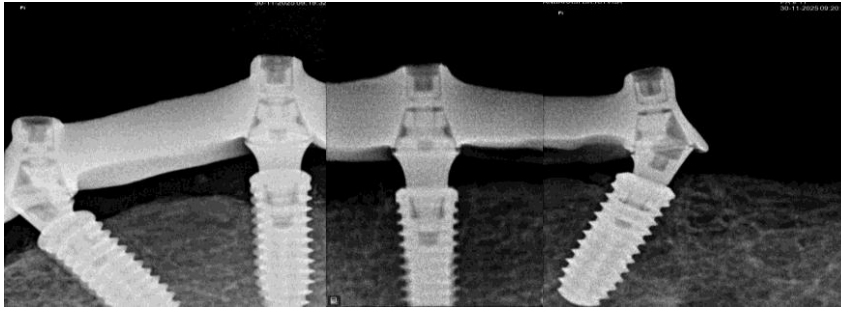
Case 2 Radiographic verification of the seating of the prosthesis.
